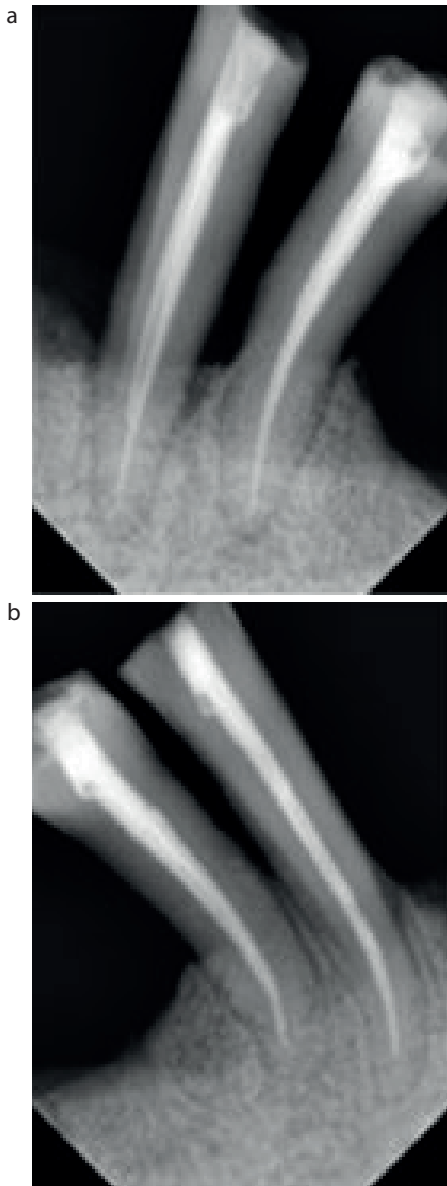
IOPA radiographs of (a) LL3, LL4 and (b) LR3, LR4 following endodontic treatment.
